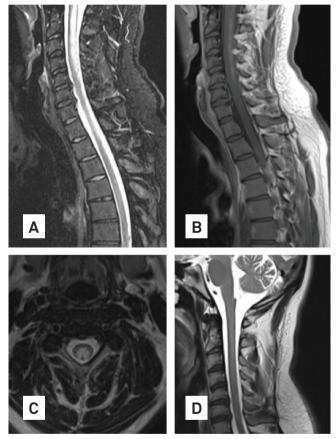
Spinal cord MRI: (A) extensive swelling of spinal cord, caused by vacuolization of myelin; (B) subtle contrast enhancement of posterior column; (C) cross-section images of spinal cord MRI: bilateral paired areas of hyperintensity affecting dorsal and lateral columns; (D) three months after treatment: significant improvement of lesions, with mild and no gadolinium enhancer T2 hyperintensity extending from bulbomedular transition until C7 without spinal cord expansion.
